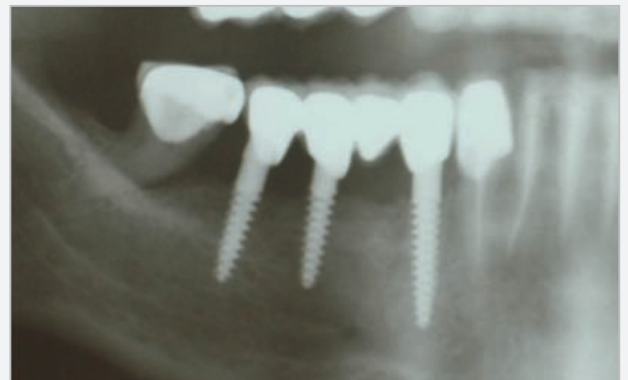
2 Year postoperative x-ray.
